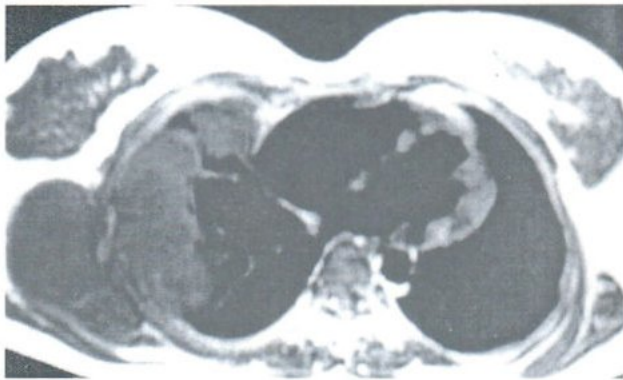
Axial MRI of the chest in T1W revealed hyposignal intensity soft tissue mass at right anterior chest wall with irregular border and invasion into thoracic cages.
